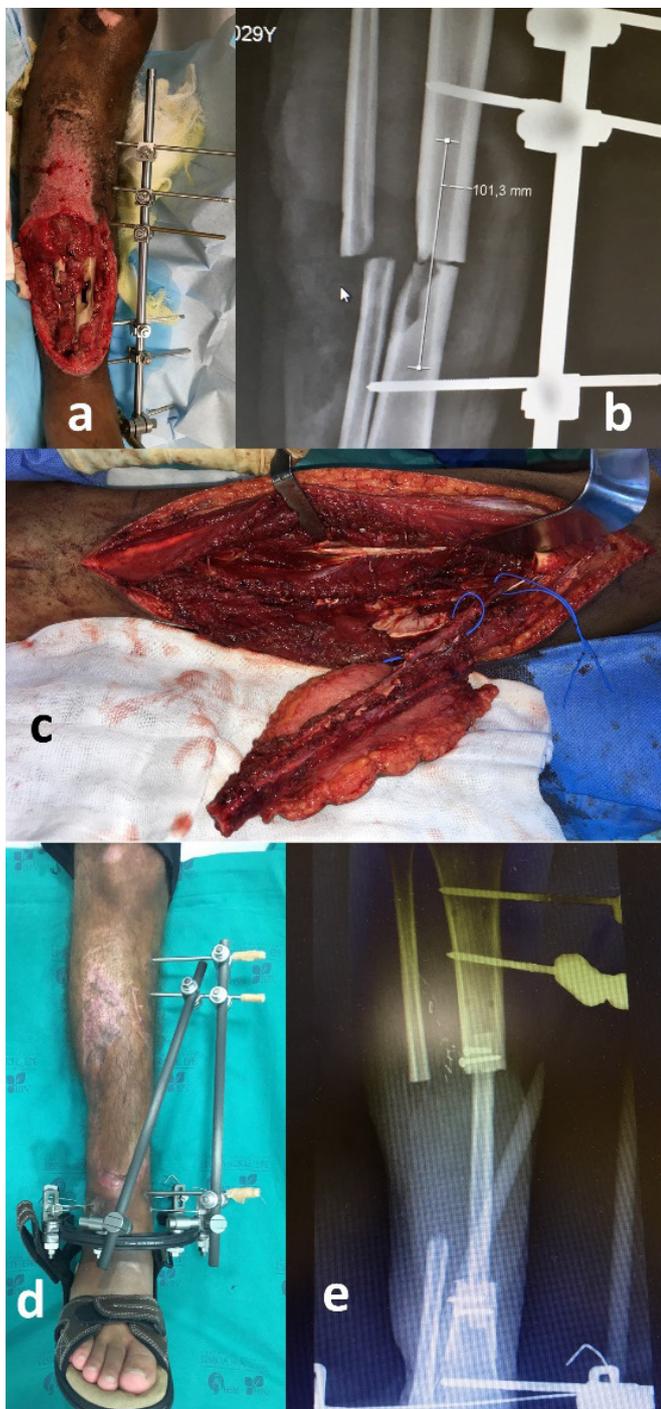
Twenty-six-year-old patient with ulcerated osteomyelitis of the right tibia and fibula. Treated by Doctor Carlos Pinheiro and a team of orthopaedic surgeons at Centro Hospitalar Universitário Lisboa Norte. Treatment consisted of wide resection of infected bone and soft tissues, and reconstruction with a contra lateral free flap. a, b: preoperative view and X-ray. c: dissection of a contralateral osteo-septo-cutaneous fibular flap for microvascular transfer: d, e: Postoperative view and X-ray
